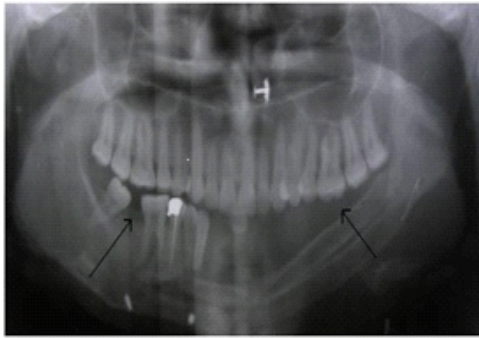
Preoperative panoramic radiograph shows mandibular continuity defect extending from right lateral incisor region to left angle region
